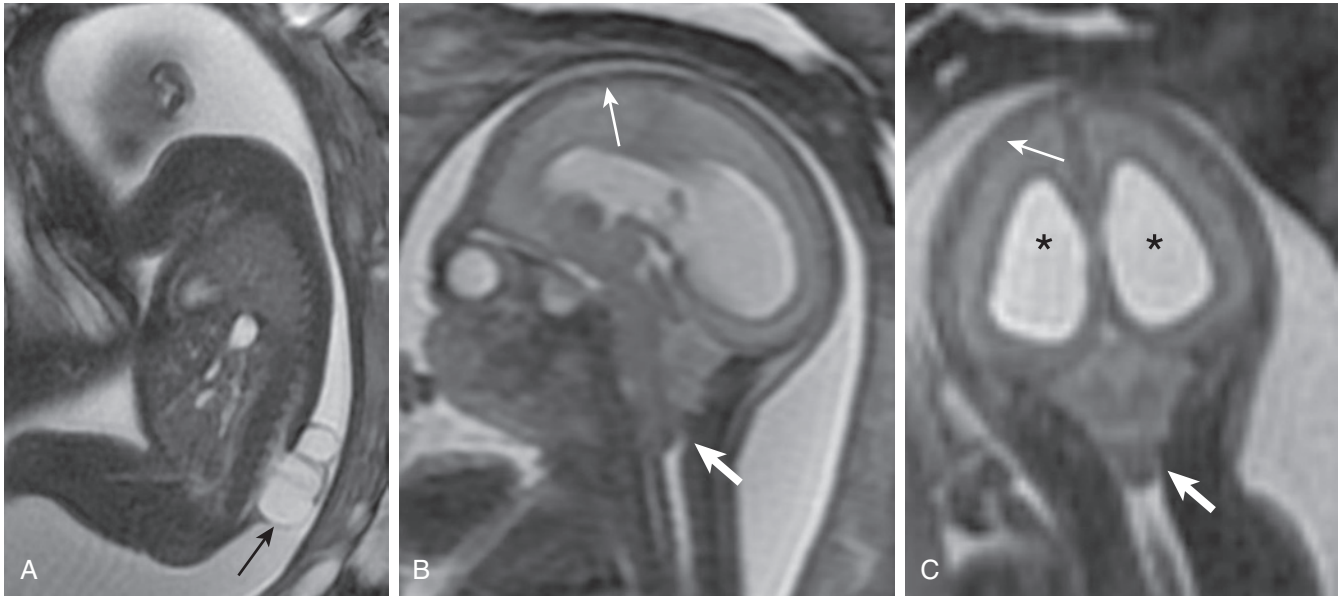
Lumbar myelomeningocele. T2-weighted fetal magnetic resonance imaging showing (A) sagittal view of the lumbar myelomeningocele (arrow); (B) sagittal and (C) coronal views of the crowded posterior fossa with downward herniation of the brain stem and cerebellum (Chiari II) (black arrow), paucity of extraaxial cerebrospinal fluid (thin arrows) around the brain, and moderate hydrocephalus (*).
